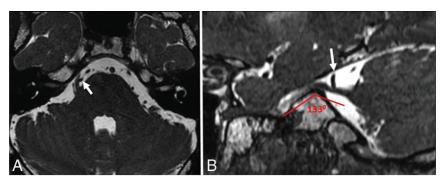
Sample measurement of the sagittal angle of the trigeminal nerve at the porus trigeminus (SATNaPT) in a 53-year-old man with right TN. A, Axial steady-state free precession (SSFP) MR image shows indentation and displacement of right trigeminal nerve (grade III) by the right superior cerebellar artery (white arrow). B, Sagittal SSFP image shows a SATNaPT of 133° with indentation on the right trigeminal nerve by the right superior cerebellar artery (white arrow).
